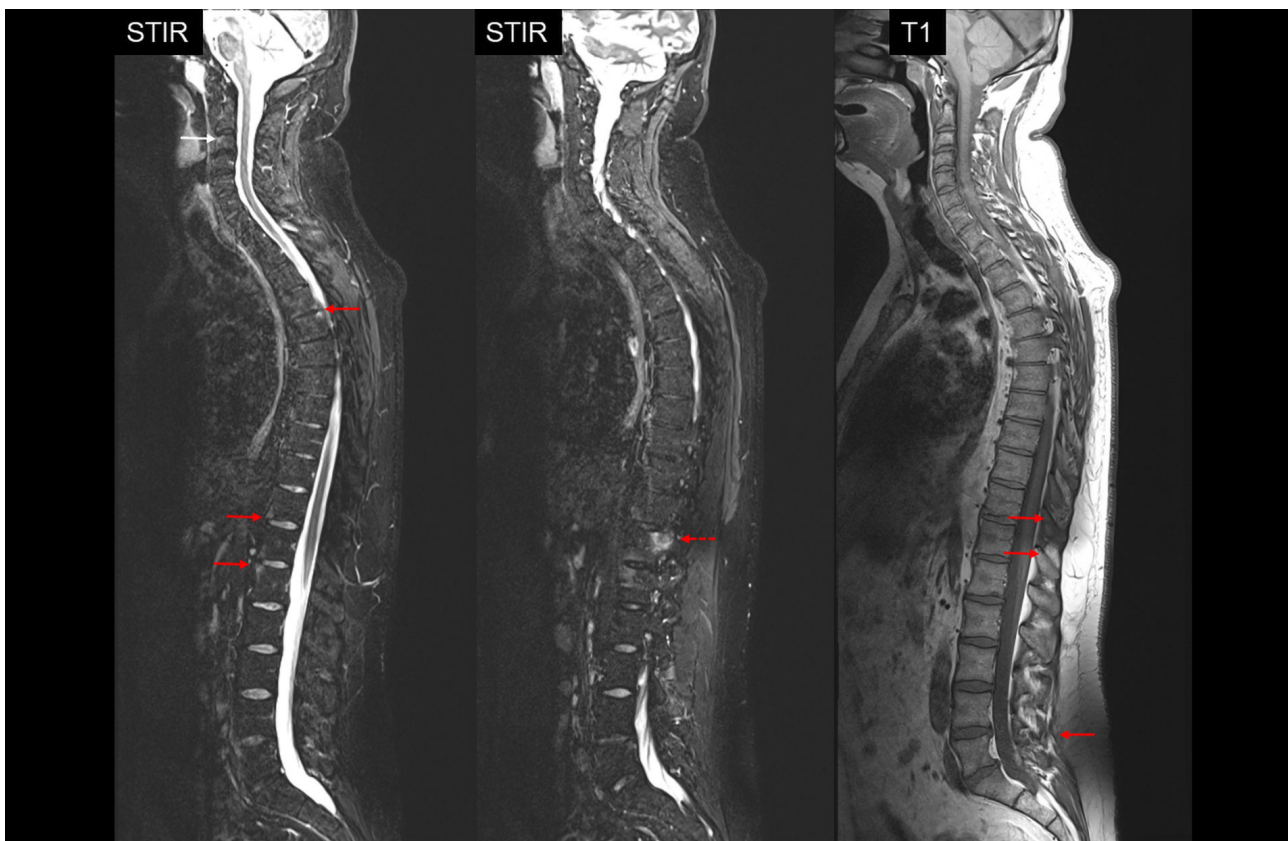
Active inflammatory and structural changes on magnetic resonance imaging (MRI) of the spine in axial spondyloarthritis (axSpA). MRI of the sacroiliac joints of a 52-year-old male patient axSpA. On STIR, active inflammatory changes—spondylitis anterior and posterior are present (solid arrows), as well as highly specific for axSpA arthritis of the costovertebral joint (dotted arrow). T1 shows some fat lesions and possible syndesmophytes (arrows)
